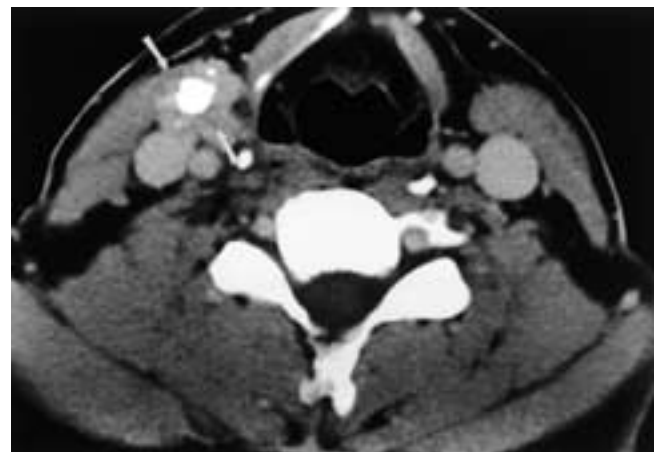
Metastatic papillary carcinoma. Enhanced axial CT image shows a calcified right cervical nodal metastasis (*arrows*).
